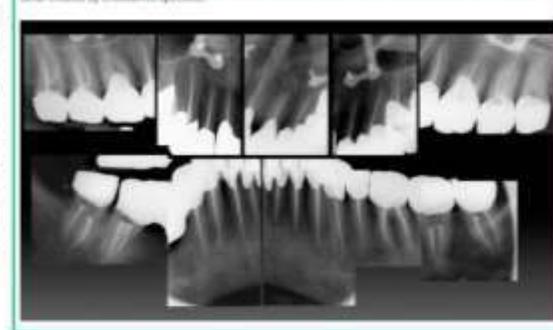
Radiographic situation after retractable pain for seven months led patient to request all teeth to be root canal treated by endobiotic specialist
